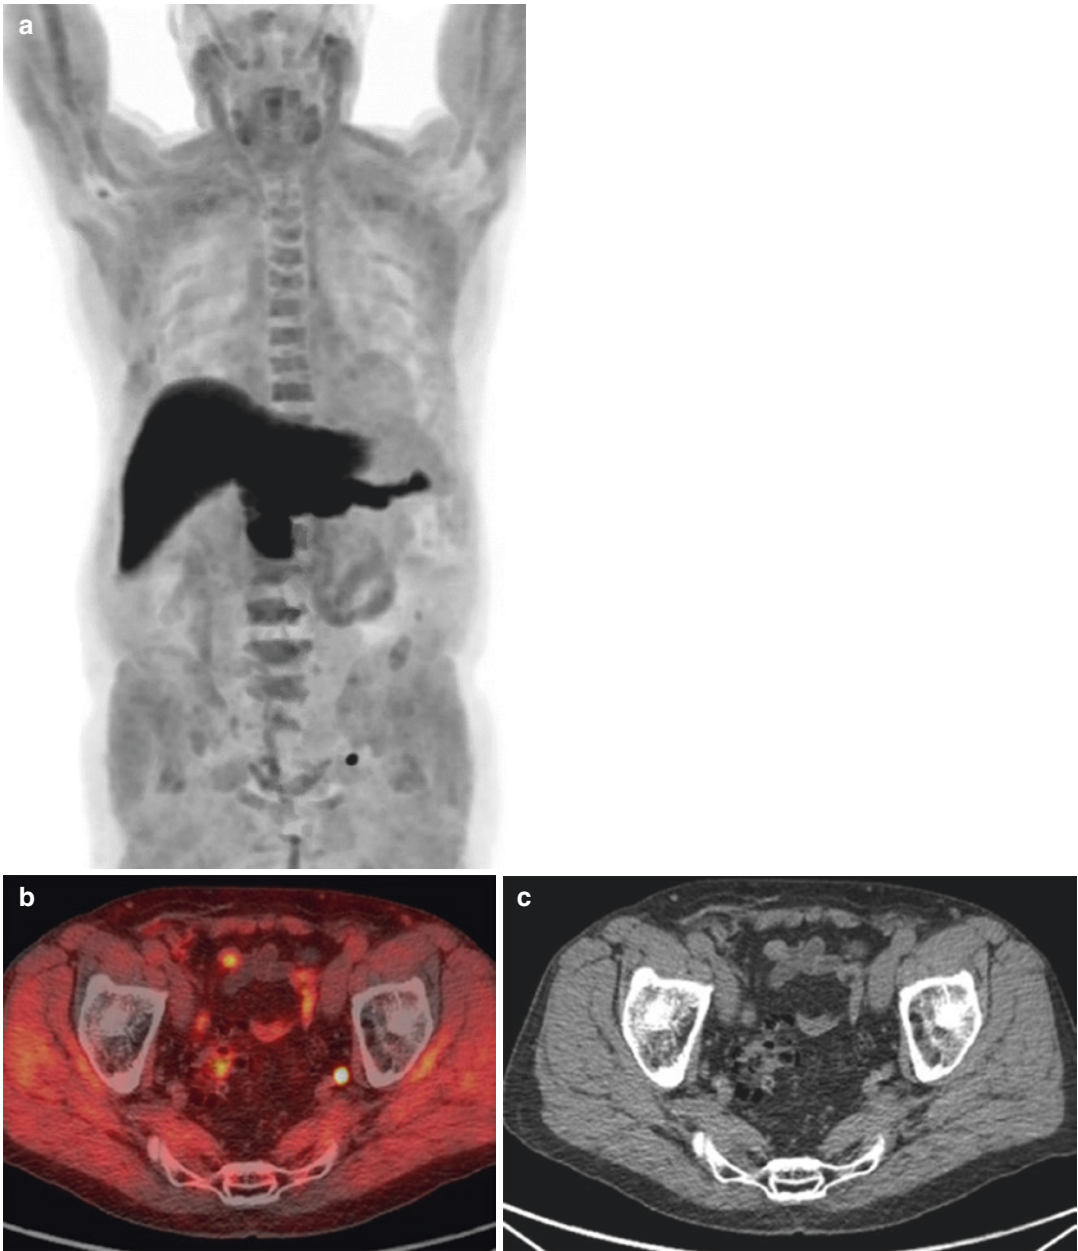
76-year-old male with biochemically recurrent prostate cancer (PSA 0.4) after radical prostatectomy. Fluciclovine PET-CT maximum intensity projection (MIP) image (a), fused PET-CT (b) and non-contrast CT
